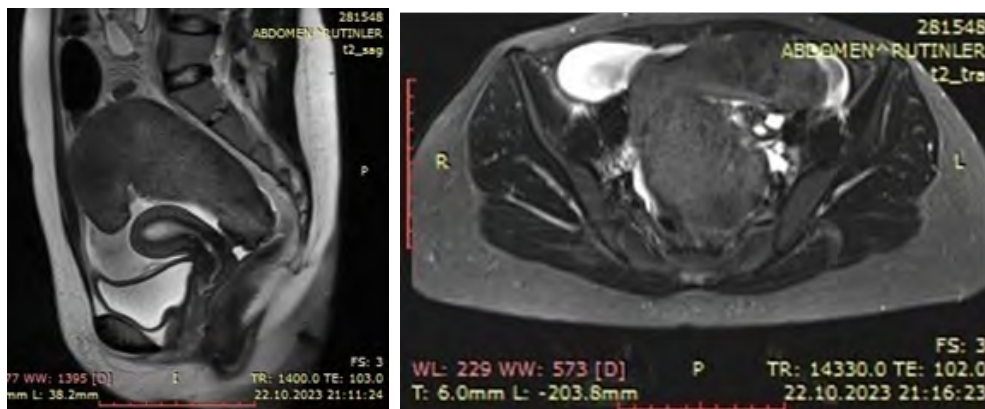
Abdominal MRI. A slightly contrasting, T1A heterogeneous isointense, T2A heterogeneous iso - slightly hypointense mass, measuring 17x12x10 cm, is observed in the posterior neighborhood of the uterus, completely filling the presacral distance.
